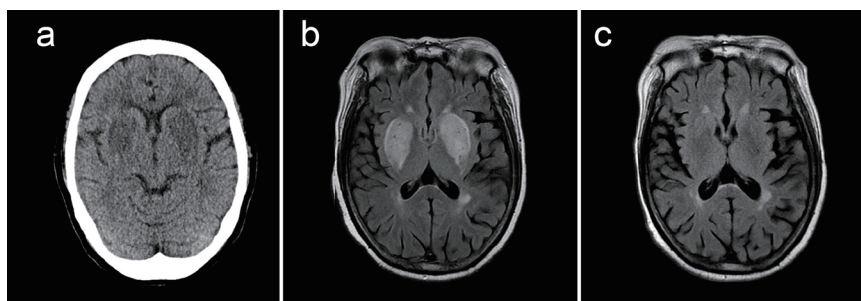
(a) Brain CT showed symmetrical hypodensities in the bilateral lentiform nuclei. (b) Brain MRI showed the bilateral basal ganglia show symmetric swelling hyperintensity on T2-FLAIR image. (c) Follow-up of brain MRI magnetic resonance imaging showed unremarkable finding in the bilateral basal ganglia.
